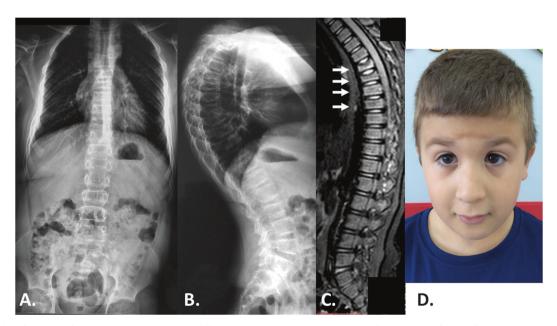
Multiple fractures of the thoracic vertebrae and diffuse osteopenia on the plain X-rays of the spine (a, b), confirmed by MRI (white arrows) (c). Photo of the index patient: blue sclerae, hypertelorism and prominent epicanthic folds (d)
